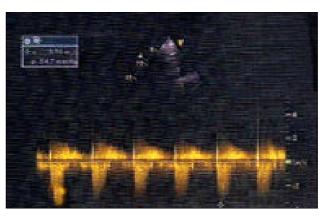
Doppler velocity showing a peak gradient of 54.7 mm Hg across the pulmonary valve.
